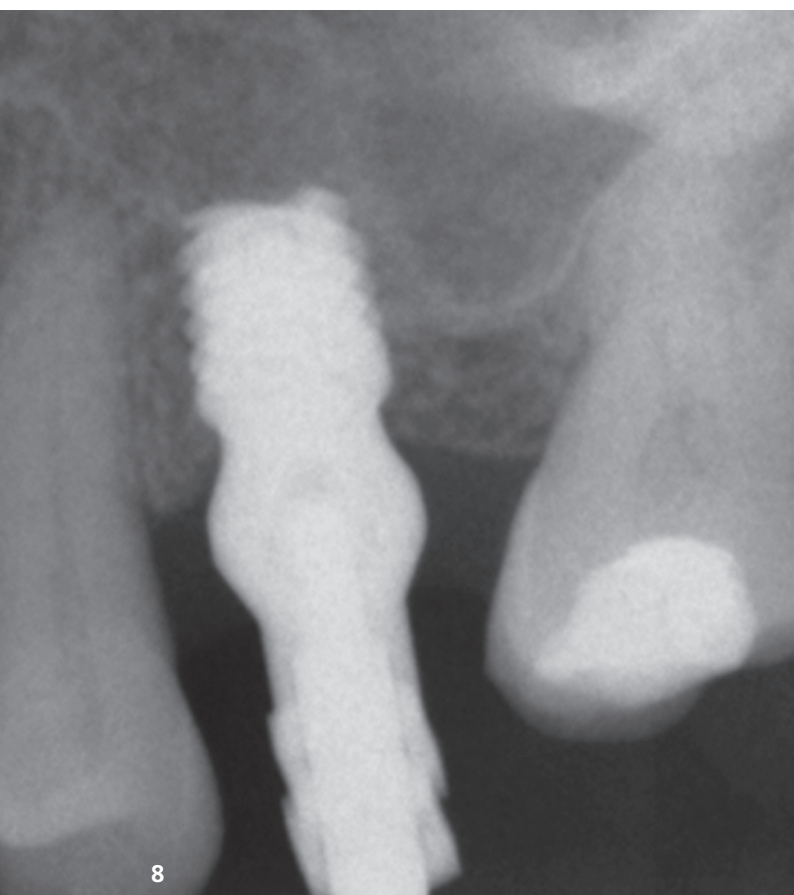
Impression of the implant with the unitary transepithelial, in this case expanded, to achieve a better adaptation of the soft tissues with this emergence profile in the making of the prosthesis. Fig. 9: X-ray two years after placement of the definitive prosthesis. The stability of the treatment can be seen.
